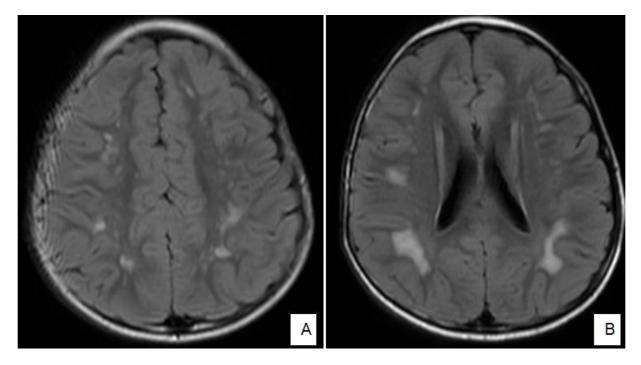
5-year-old male patient during the post-COVID recovery period, presenting with few episodes of seizures had symmetrical FLAIR and T2W hyperintensities in bilateral fronto-parietal-temporal subcortical white matter. Fig [A] and [B] show the symmetrical FLAIR hyperintensities in bilateral fronto-parietal-temporal subcortical white matter with the sparing of the U fibres. There was no corresponding restricted diffusion/ blooming in these areas. A diagnosis of post-COVID demyelinating encephalomyelitis was made based on the history and imaging findings.
